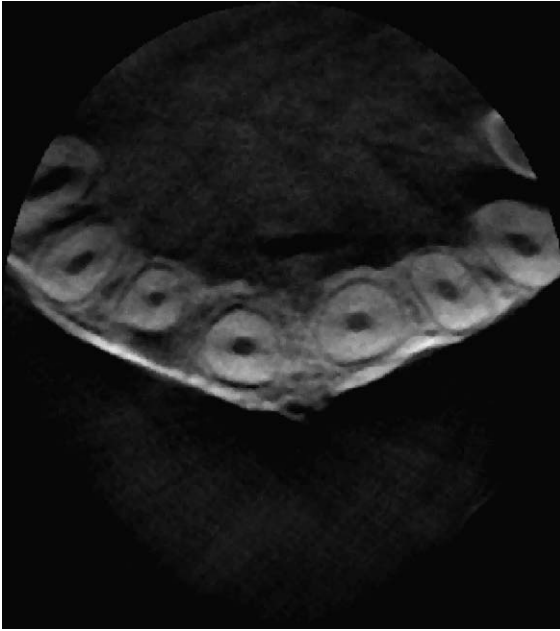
An original cone-beam CT image slice: which was exported as tiff 8 bits image format by the dedicated software 'iDixel' after adjusting the window/level and reslicing.
